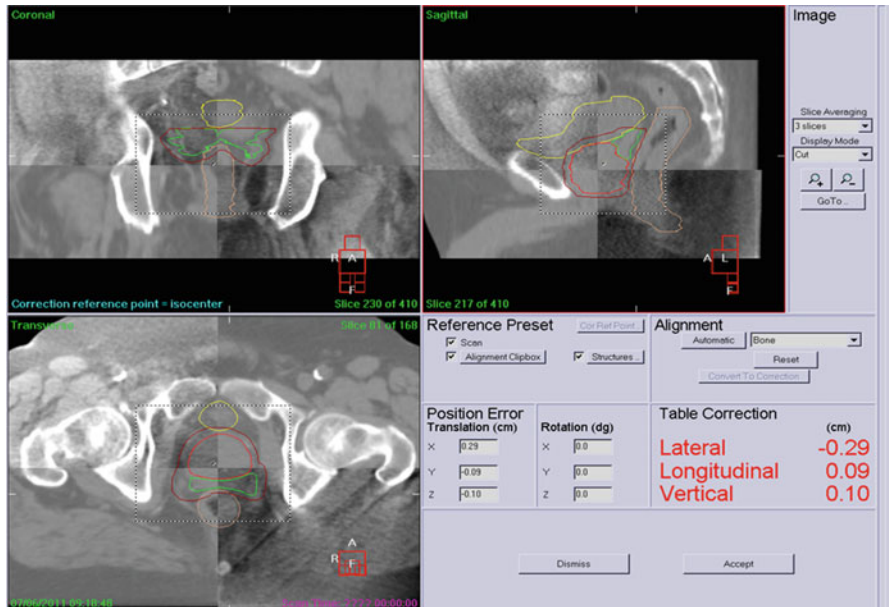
A fusion of a planning CT and a kVCBCT of a prostate patient image on Elekta X-ray volume imaging (XVI) system. Registration can be done automatically or manually using axial, sagittal, and coronal views
